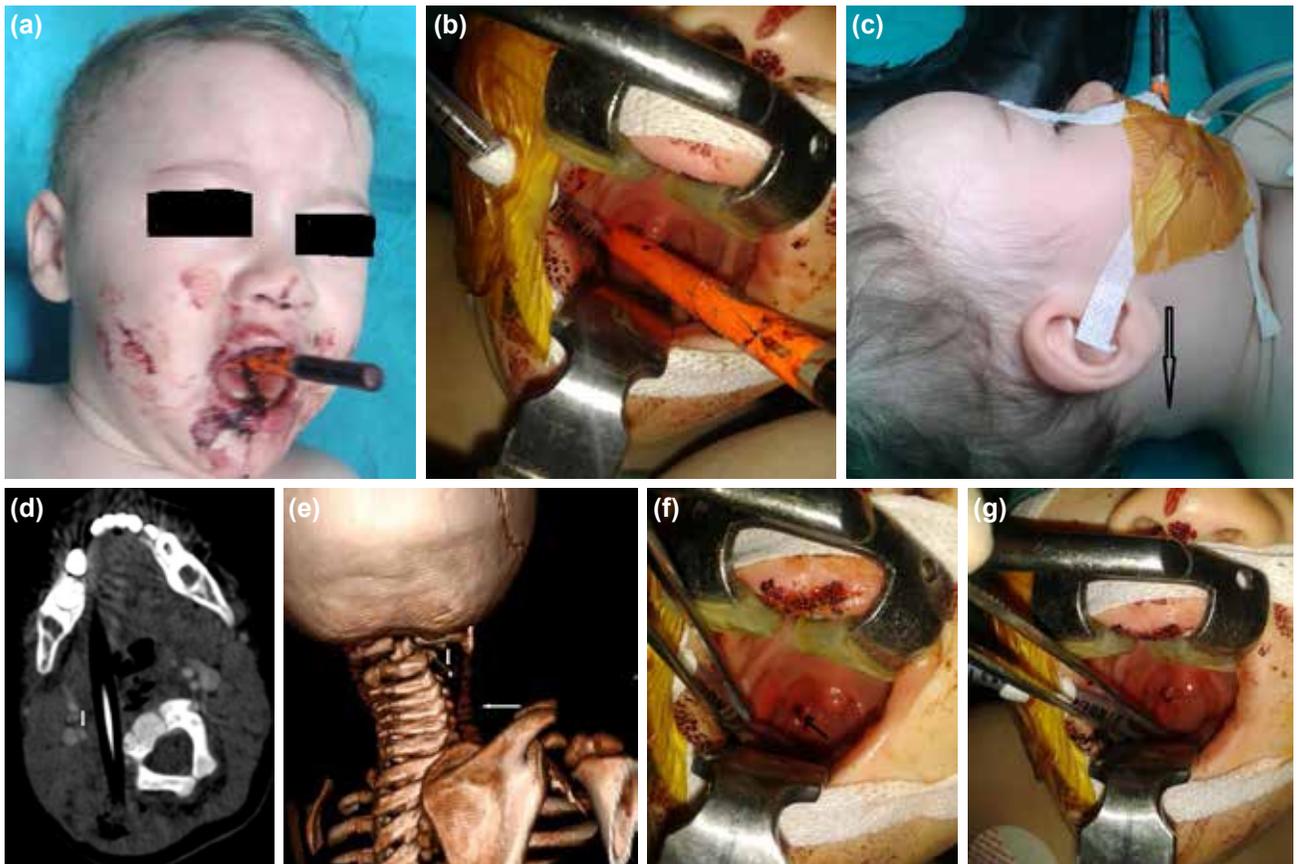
(a) Penetrated pencil is seen in the mouth. (b) Closer sight of the pencil. (c) Arrow points to end of the pencil reaching occipital area. (d) CT imaging. Foreign body and vascular structures are seen. Arrow points to carotid artery. (e) 3-D CT imaging. Upper arrow points to foreign body and below arrow points to carotid artery. (f) Oropharynx after removing the pencil. (g) Sutured area in the oropharynx.
